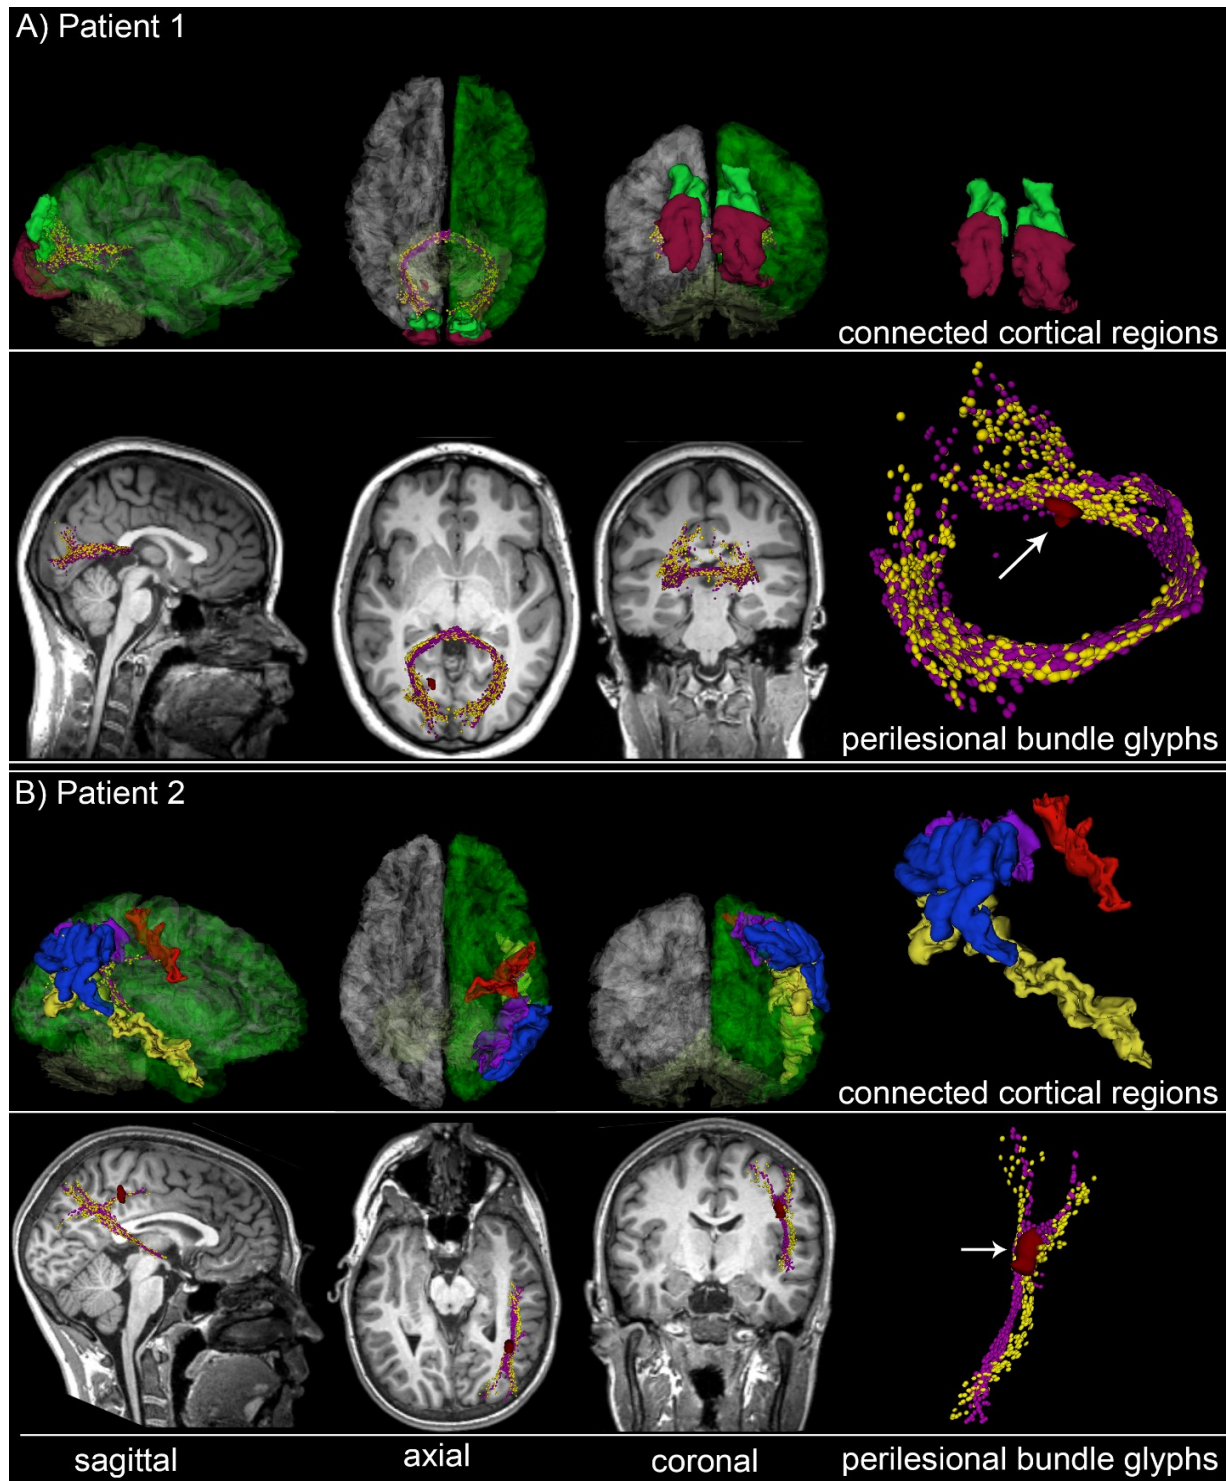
Reconstructions of DTI streamline bundles (acute: yellow; chronic: magenta) which are adjacent to CMBs identified in two mTBI victims (Patient 1: A and B; Patient 2: C and D). Cortical models (translucent green) are overlaid onto T1-weighted images to assist with the visualization of CMB locations relative to brain landmarks and to the trajectories of perilesional streamlines. Cortical regions innervated by perilesional streamline bundles are shown as well, both in relation to the entire cortex (sagittal, axial, coronal views, left three columns) and separately (rightmost column).
